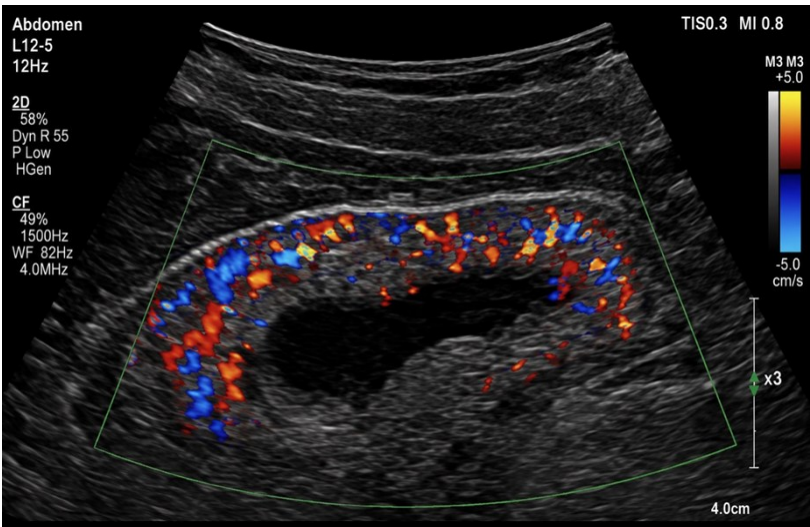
Color Doppler ultrasound showing increased mural vascularity.
